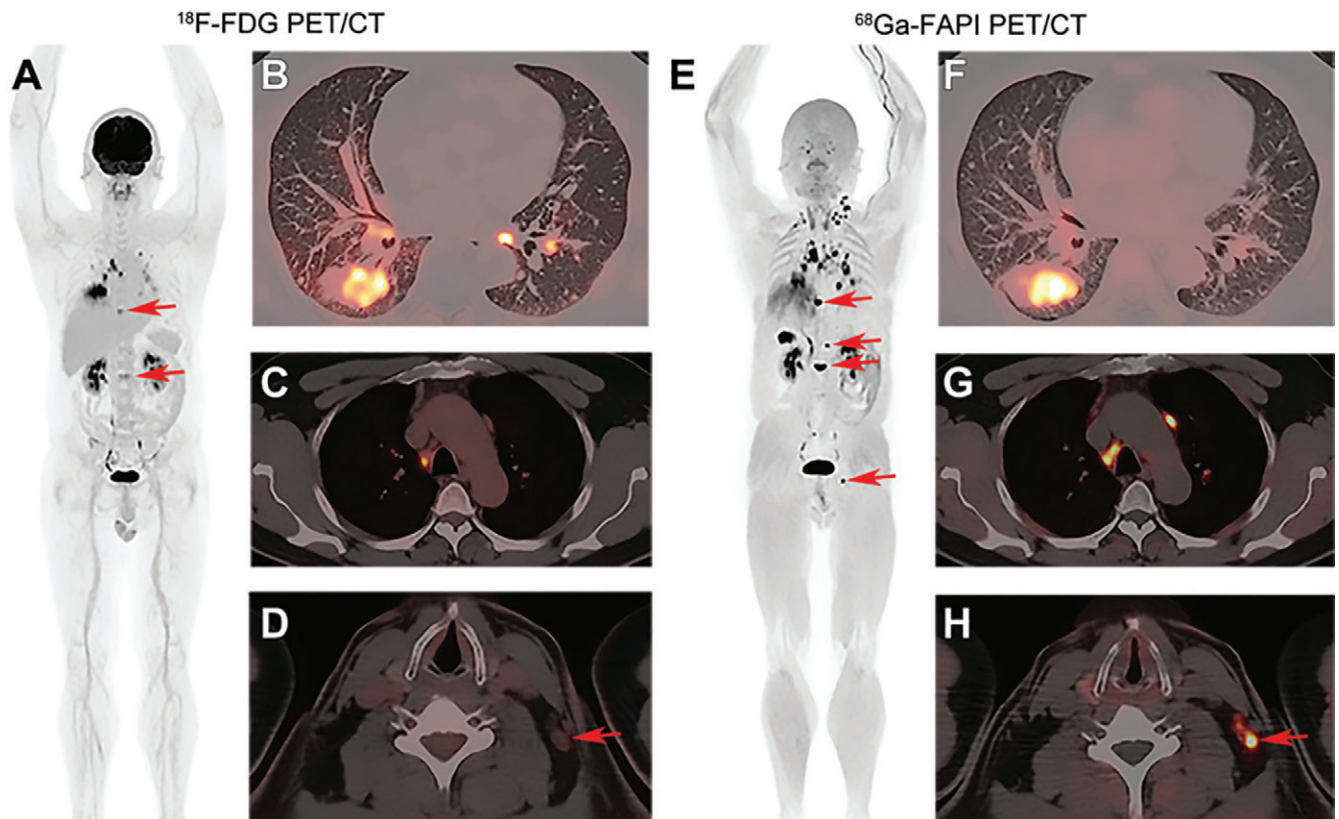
Images in a 46-year-old man with newly diagnosed lung adenocarcinoma for tumor staging. (A) Fluorine 18 (^{18}F)-labeled fluorodeoxyglucose (FDG) maximum intensity projection PET image, (B) axial fused ^{18}F -FDG PET/CT image of lung, and (C, D) axial fused ^{18}F -FDG PET/CT images of mediastinum and neck. (E) Gallium 68 (^{68}Ga)-labeled fibroblast activation protein inhibitor (FAPI) maximum intensity projection image, (F) axial fused ^{68}Ga -FAPI PET/CT image of the lung, and (G, H) axial fused ^{68}Ga -FAPI images of mediastinum and neck. Primary lung cancer (size, 4.9×4.2 cm) in the lower lobe of right lung was detected with intense uptake of ^{18}F -FDG and ^{68}Ga -FAPI (maximum standardized uptake value, 10.4 and 12.4) (A, B, E, F). Multiple small lung metastases were also observed with both techniques (B, F). ^{18}F -FDG PET/CT images show multiple positive lymph nodes in right hilum and mediastinum (A, C). ^{68}Ga -FAPI PET/CT images depict more positive lymph nodes not only in right hilum and mediastinum (E, G) but also in the left lower neck (H, arrow), which is negative on ^{18}F -FDG PET/CT image (D, arrow). Maximum intensity projection ^{68}Ga -FAPI PET/CT image depicts four bone metastases in the thoracic spine, lumbar spine, and left iliac bone (E, arrows), whereas maximum intensity projection ^{18}F -FDG PET/CT image only depicts two lesions in the thoracic and lumbar spine with much lower tracer uptake (A, arrows) (Reprinted, with permission, from reference 27.)
